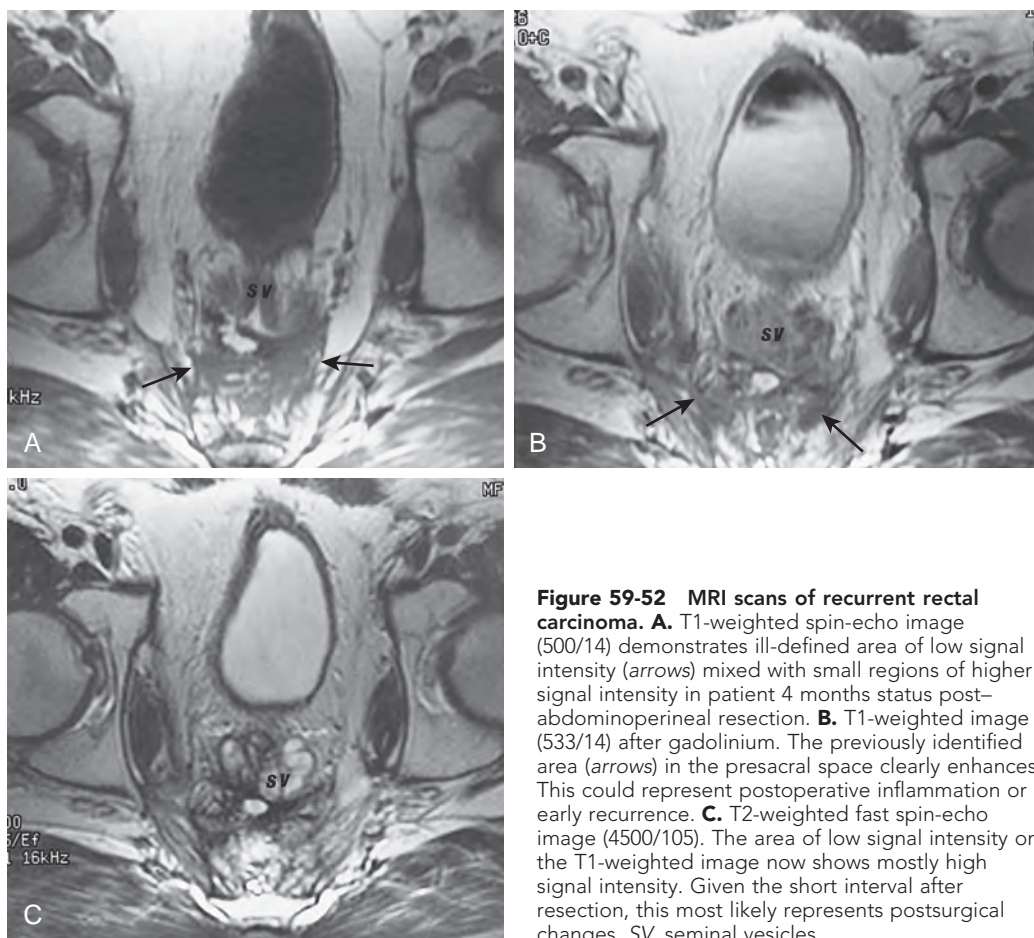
MRI scans of recurrent rectal carcinoma. A. T1-weighted spin-echo image (500/14) demonstrates ill-defined area of low signal intensity (arrows) mixed with small regions of higher signal intensity in patient 4 months status post-abdominoperineal resection. B. T1-weighted image (533/14) after gadolinium. The previously identified area (arrows) in the presacral space clearly enhances. This could represent postoperative inflammation or early recurrence. C. T2-weighted fast spin-echo image (4500/105). The area of low signal intensity on the T1-weighted image now shows mostly high signal intensity. Given the short interval after resection, this most likely represents postsurgical changes. SV, seminal vesicles.
